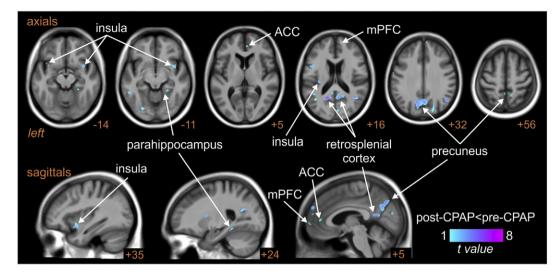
Brain regions in which fluctuations in BOLD signal intensity coupled to fluctuations in muscle sympathetic nerve activity (MSNA) were significantly different in subjects with obstructive sleep apnoea (OSA) prior to and following 6 months of continuous positive airway pressure (CPAP) treatment. Cool color scale represents regions in which changes in signal intensity during each burst of MSNA were significantly reduced following CPAP treatment. Significant clusters are overlaid onto a mean T1-weighted anatomical template image. Slice locations in Montreal Neurological Institute space are indicated at the lower right of each image. ACC: anterior cingulate cortex, mPFC: medial prefrontal cortex.
